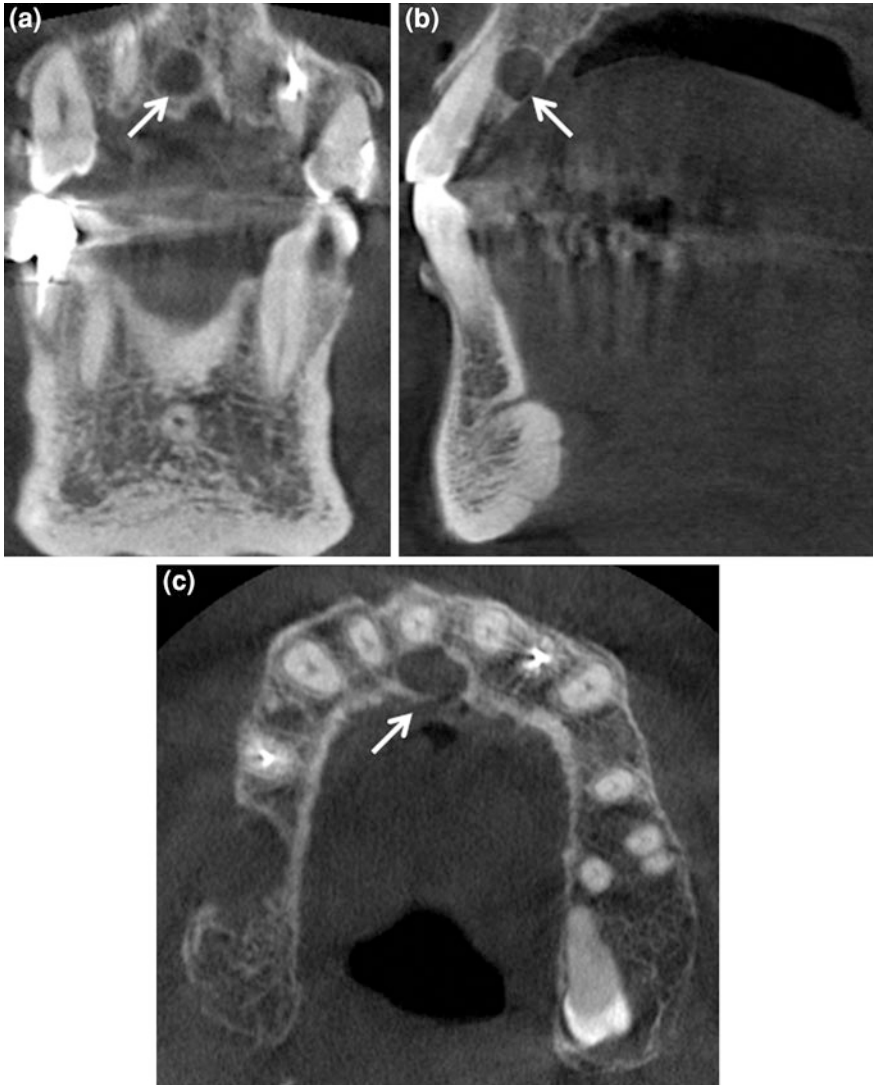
CBCT coronal (a), sagittal (b) and axial (c) scans showing in the posterior maxilla a well-defined ovoid radiolucent area with discontinuity of the palatal cortical plates (*thin arrow*). It is a nasopalatine duct cyst
